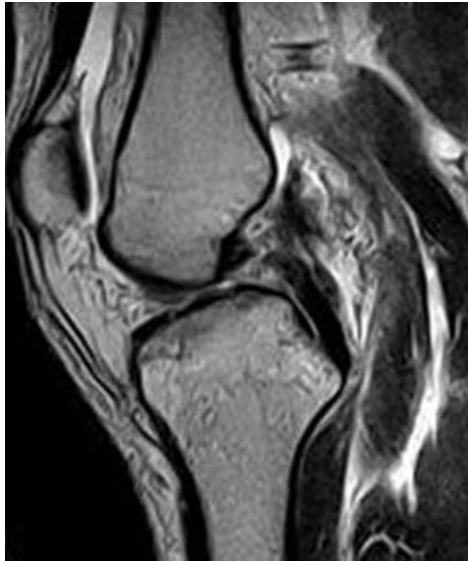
Sagittal MRI image shows a complete tear in the posterior cruciate ligament.
